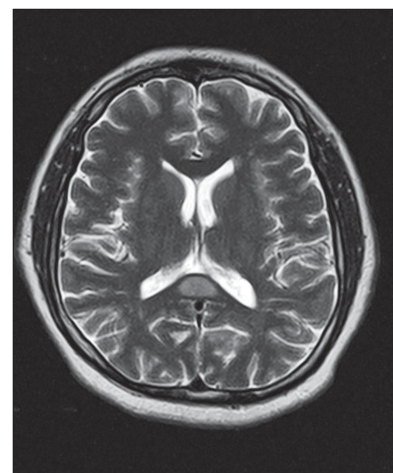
(c): Axial T2-weighted sequence shows that the lesion is homogeneously hyperintense compared to the body of the corpus callosum
